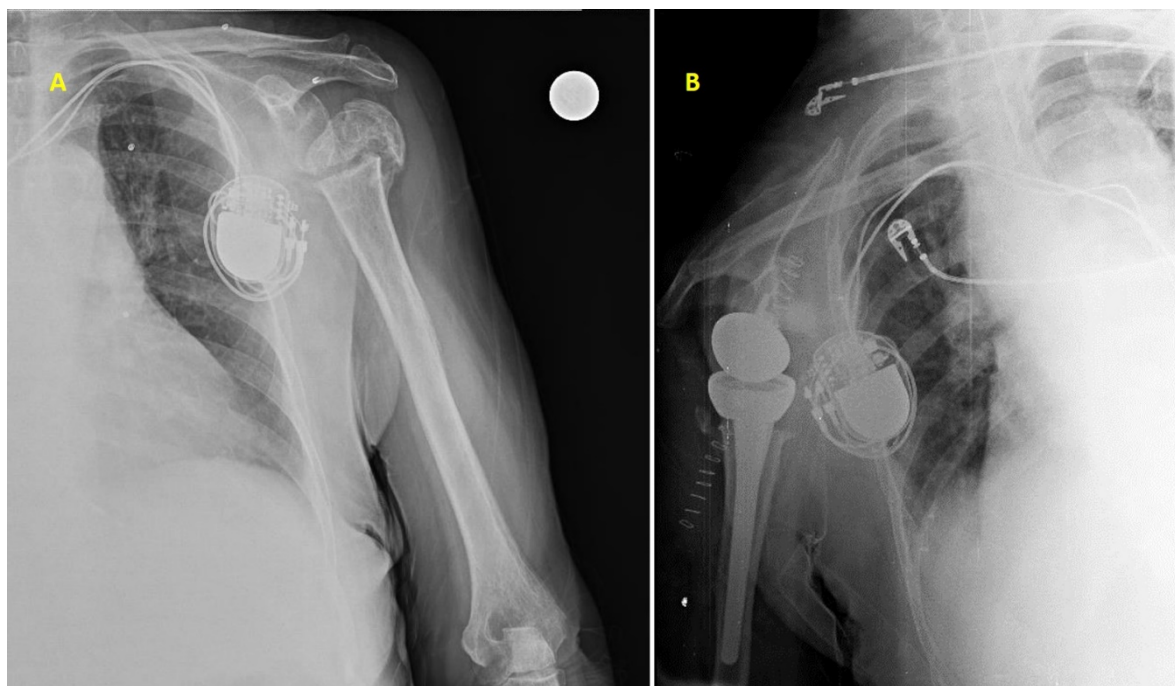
A) Patient on admission had non-union at proximal humerus; B) Postoperative radiograph after reverse shoulder arthroplasty is shown.
